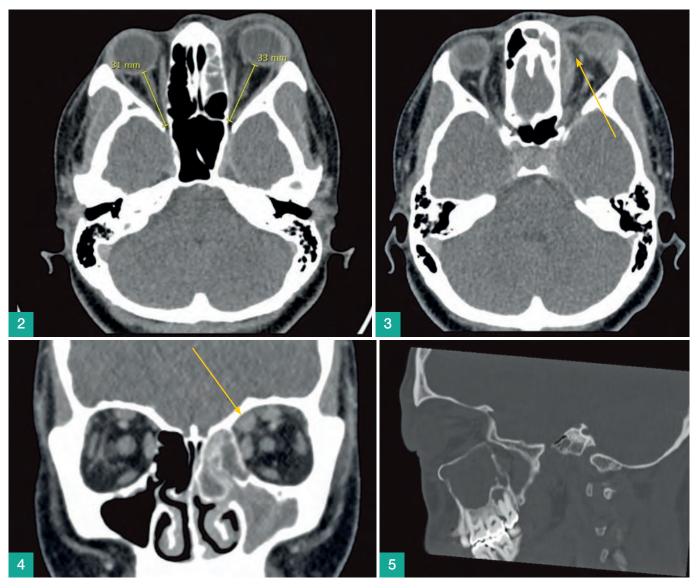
Axial slice of CT indicating proptosis of the left globe.
